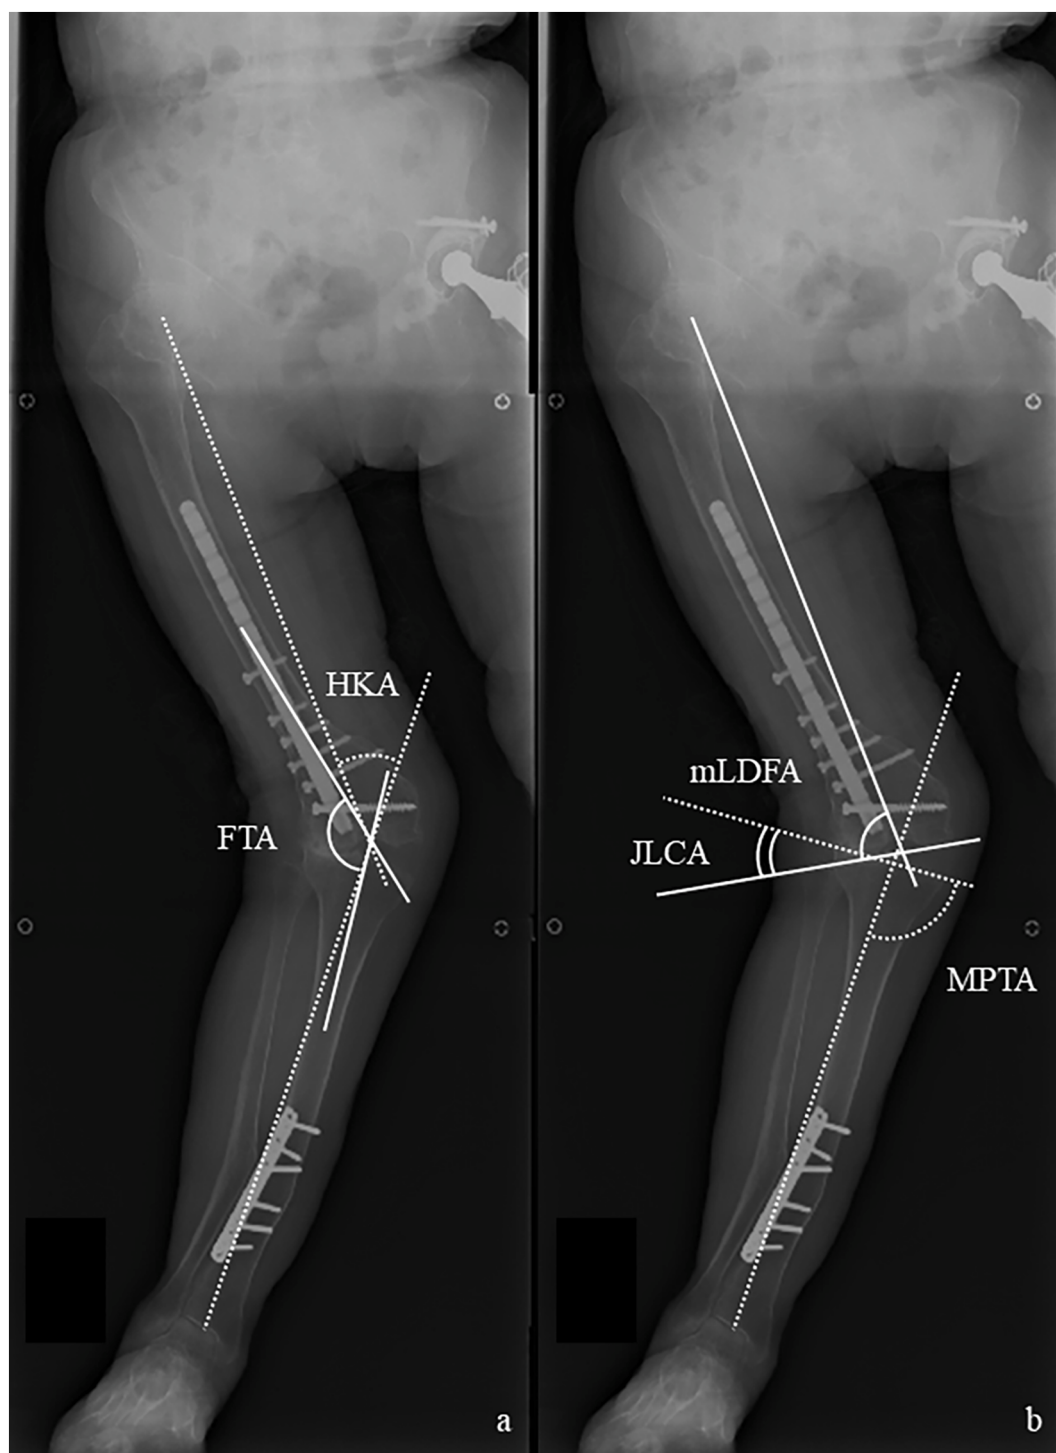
Preoperative long leg standing radiograph.
